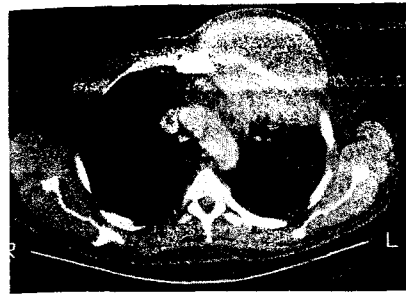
CT scan of the chest revealed a large mass involving the pectoralis muscle superficially and invading through the chest wall into the upper lobe of the left lung.
